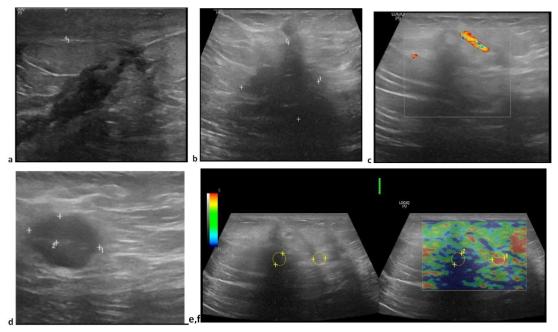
(a) Left breast diffuse increased skin thickness associated with subcutaneous and interstitial edema and echogenic fat lobule. (b) Leftilldefined speculated hypoechoic lesion posterior shadowing. (c) On color Doppler shows increase vascularity. (d) Left axilla shows suspicious looking lymph nodes globular in shaped with effaced central fatty hilum. (e) Left breast quantitative elastography shows SR 6. (f) Left breast qualitative elastography shows E score 4.
